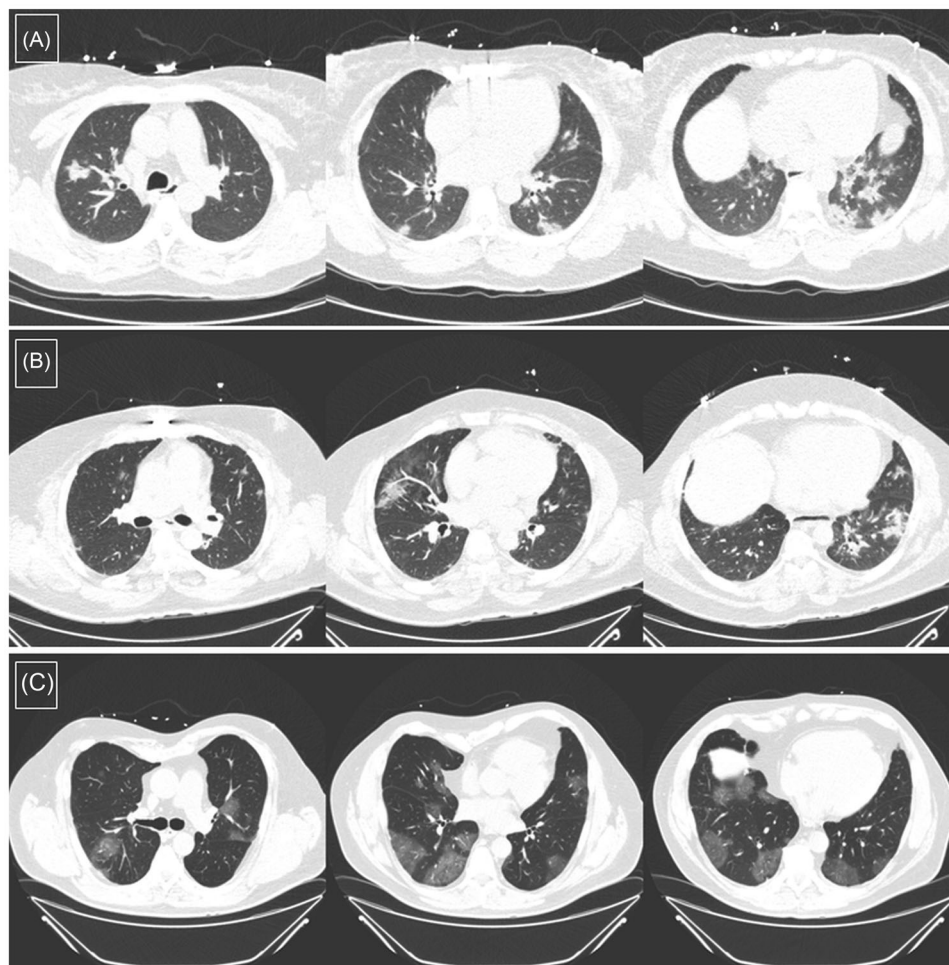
(A) CT chest in fully vaccinated patients with breakthrough COVID-19 at day 5 of hospitalization (8 days after symptom onset). (B) CT chest in another fully vaccinated patients with breakthrough COVID-19 at day 5 of hospitalization (9 days after symptom onset). (C) CT chest in an unvaccinated patient with COVID-19 at day 3 of hospitalization (9 days after symptom onset).
